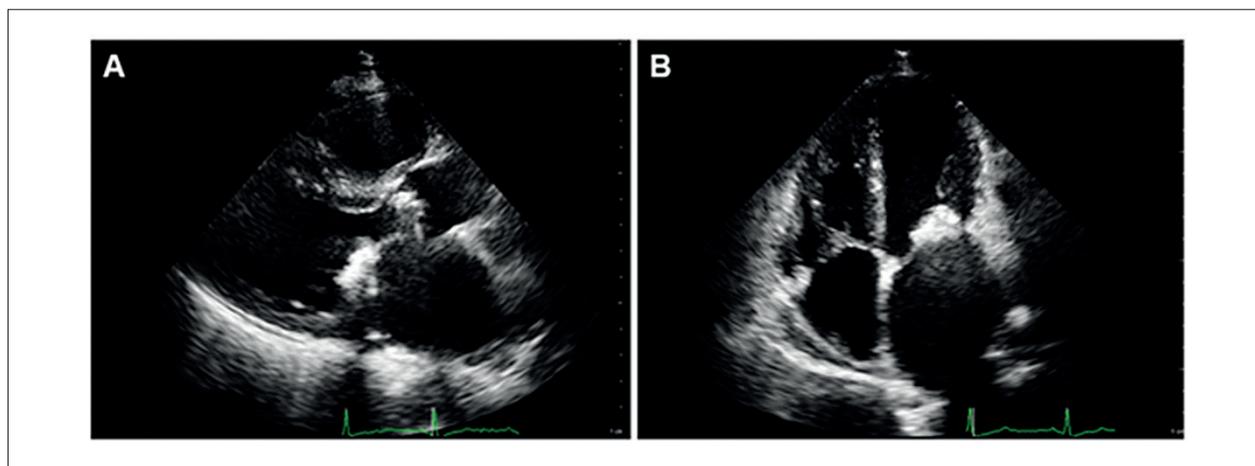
Valvular calcification. Echocardiographic images show the calcification of the mitral valve leaflets, affecting their medial and distal portions, with preservation of the base, demonstrated in the parasternal long-axis view (A) and in the apical four-chamber view (B). It is important to note that, in this case, the calcification is restricted to the leaflets, without commissure involvement, which does not constitute a contraindication to PMBV.
